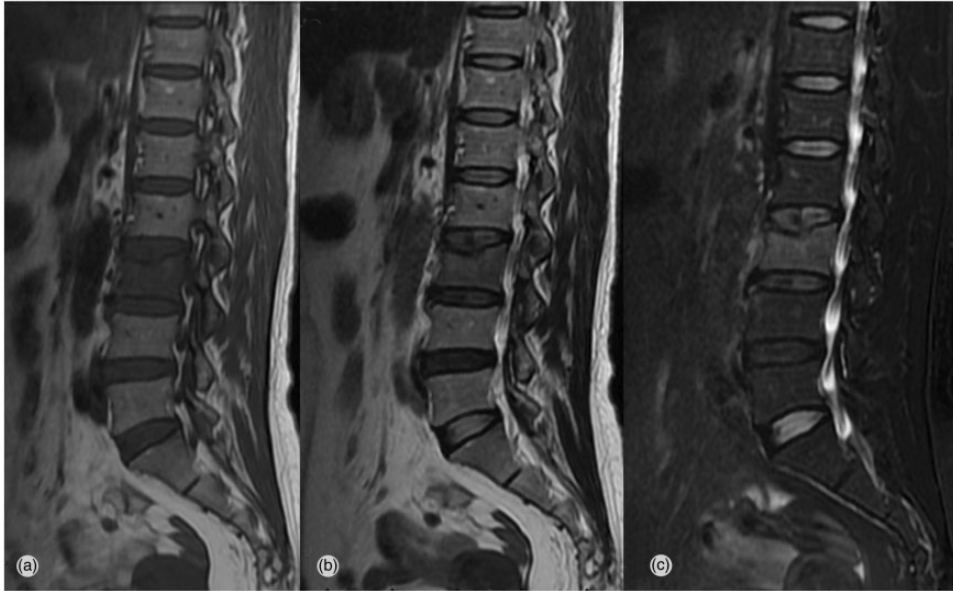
A 54-year-old woman with an osteoporotic compression fracture at L3. T1-weighted (a), T2-weighted (b), and fat suppression (c) sagittal magnetic resonance images show a fresh compression fracture at the L3 level.
